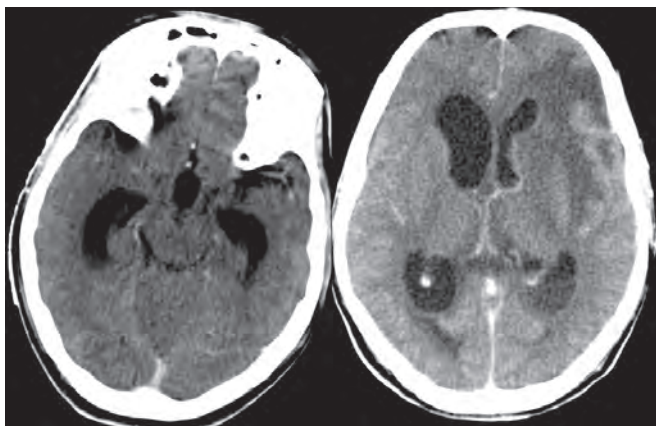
CT scan of the brain showing meningitis with ventriculitis
